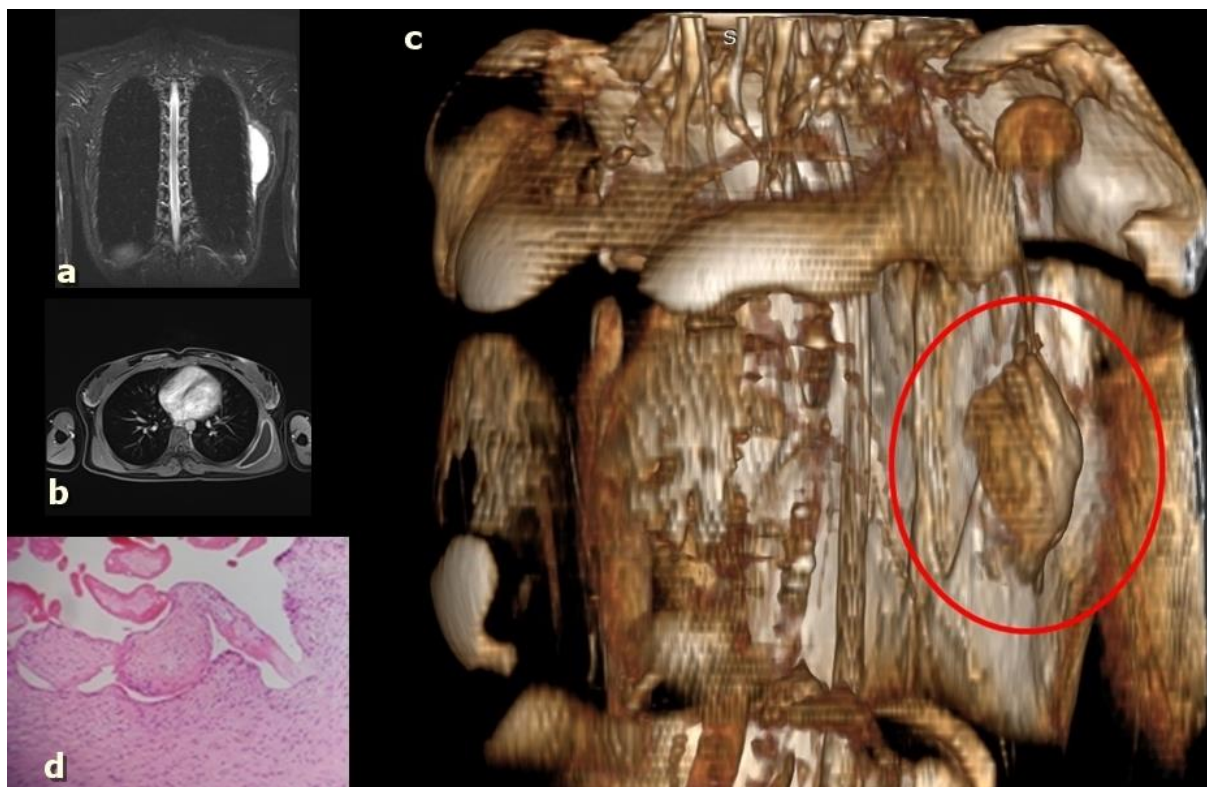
a-b. Thorax MRI images c.3D reconstruction image d.The cyst wall is composed of thick fibrous tissue with an epithelial lining (HEX200)
